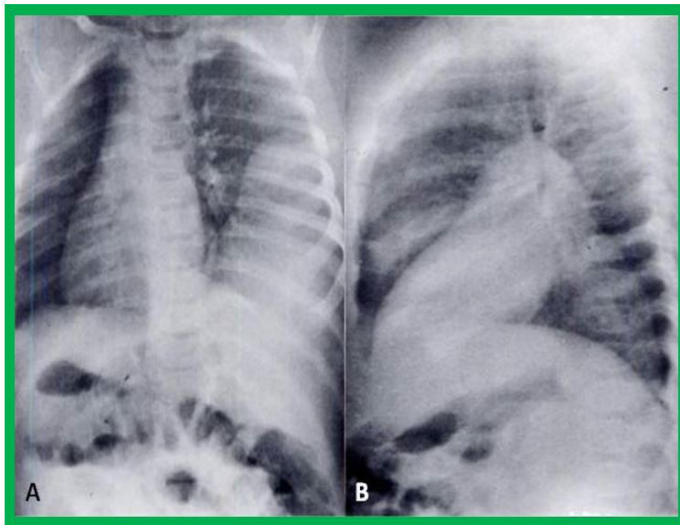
Chest x-ray in postero-anterior view demonstrating a diffuse parenchymal reticular pattern with multifocal areas of radiolucency. This roentgenographic pattern, along with the clinical findings, is essentially diagnostic of the Wilson-Mikity syndrome.
